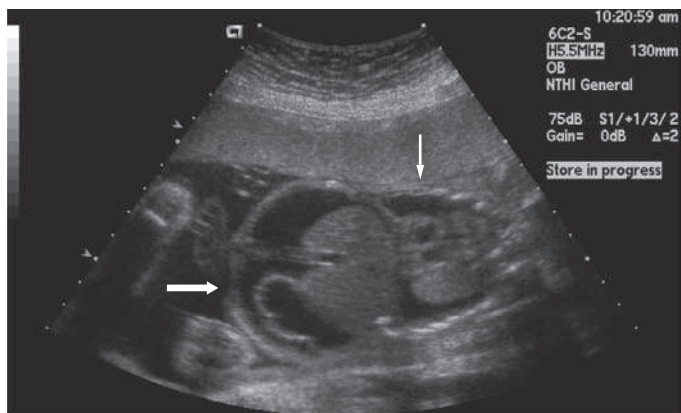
Hydrops fetalis. Longitudinal sonographic image of the fetus, with ascitic fluid outlining the liver (large arrow). The small arrow shows pleural effusion above the diaphragm. (From Wilkins I. *Nonimmune hydrops*. In Creasy RK, Resnick R, Iams JD, et al., eds. *Creasy & Resnick's Maternal-Fetal Medicine*, 7th ed. Philadelphia: Elsevier; 2014: Fig. 37-2.)
